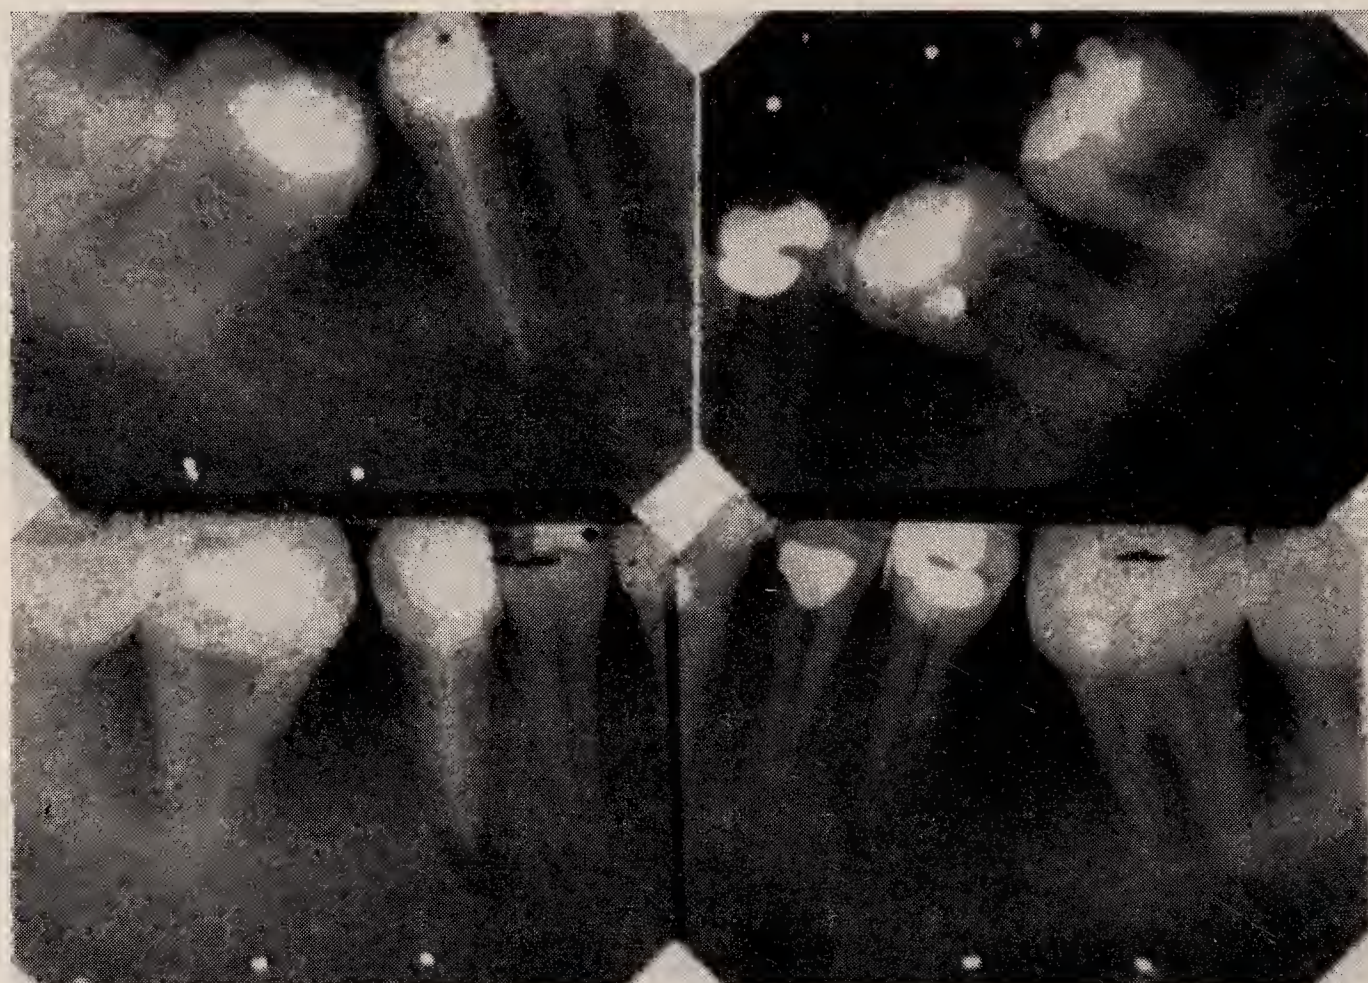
Case 4. Radiographs to show bone supporting 87|78 before (*upper*) and after (*lower*) treatment.
